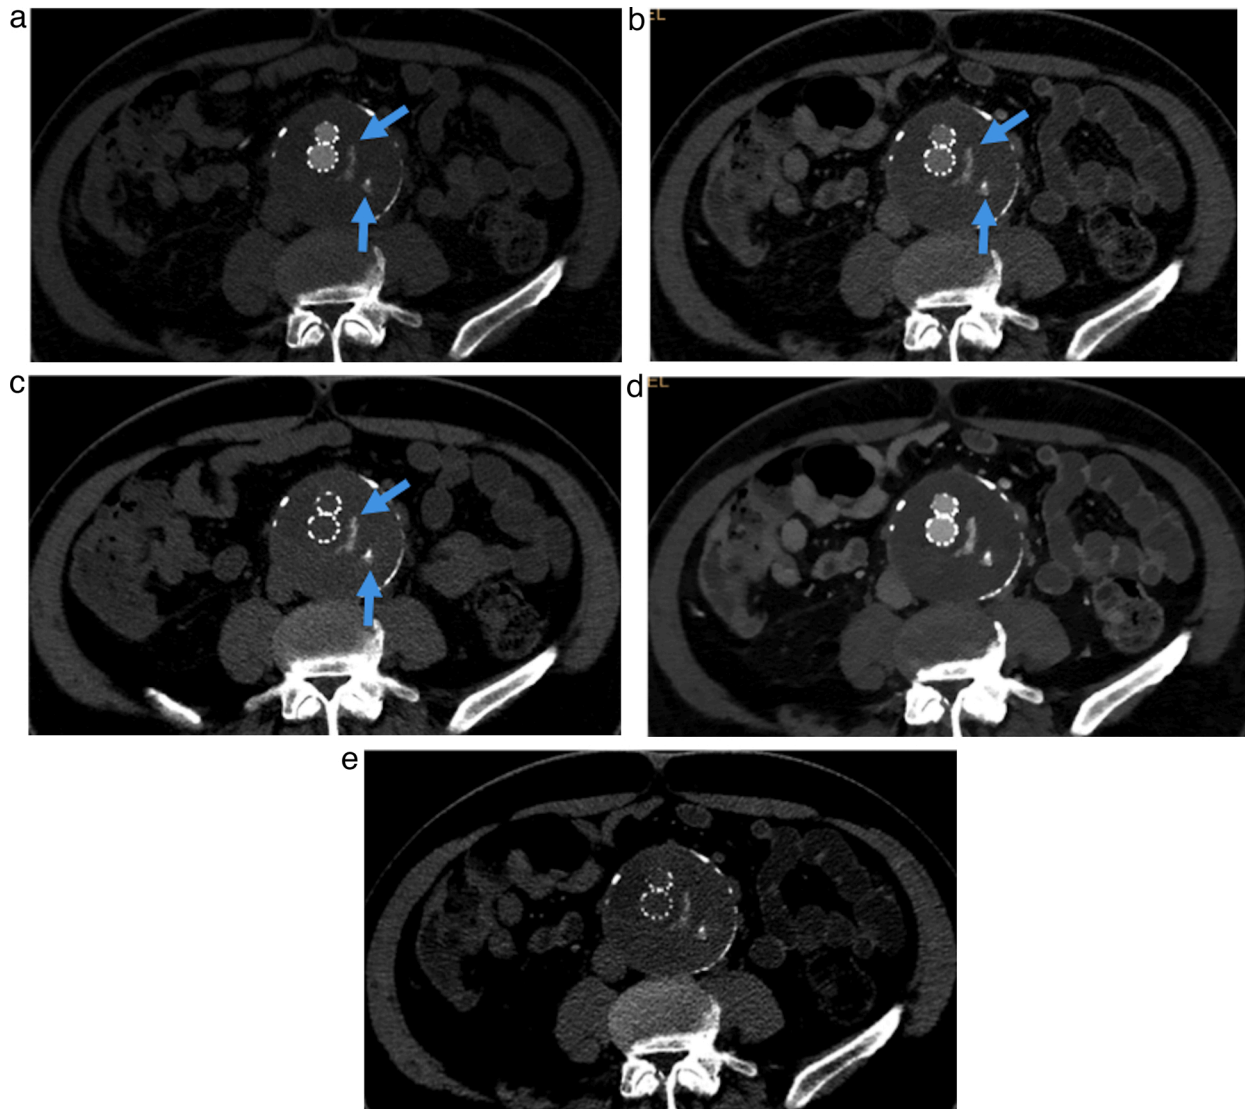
Radiation dose reduction with DECT. A 64-year-old male with history of endovascular aneurysm repair (EVAR) for abdominal aortic aneurysm (AAA), underwent a follow up three phase CT angiogram (non-contrast, arterial phase and delayed phase scanning) of the abdomen and pelvis. Axial arterial phase image (a) demonstrates areas of hyperattenuation outside the stent in the excluded abdominal aortic aneurysm (Arrows), which persists on true non-contrast (TNC) image(c) and does not change on delayed contrast enhanced image (b). The findings are consistent with calcification in the excluded AAA and not an endoleak. When utilizing the low keV VM image (d) and VNC (e) reconstructions from the single delayed phase examination (b), comparable information to a three-phase scan can be obtained, thus, there is a potential of significantly reducing radiation exposure to the patient.
